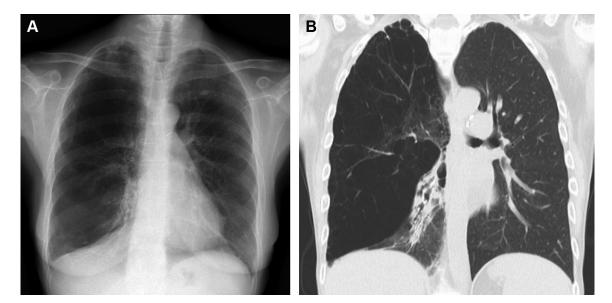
A, Posterior-anterior chest radiograph in a 66-y-old woman with severe emphysema and status post unilateral left lung transplant showing unilateral hyperlucency in native right lung with underlying emphysema. B, Coronal CT image on lung windows showing the hyperexpanded right lung with underlying emphysema and transplanted normal left lung.
